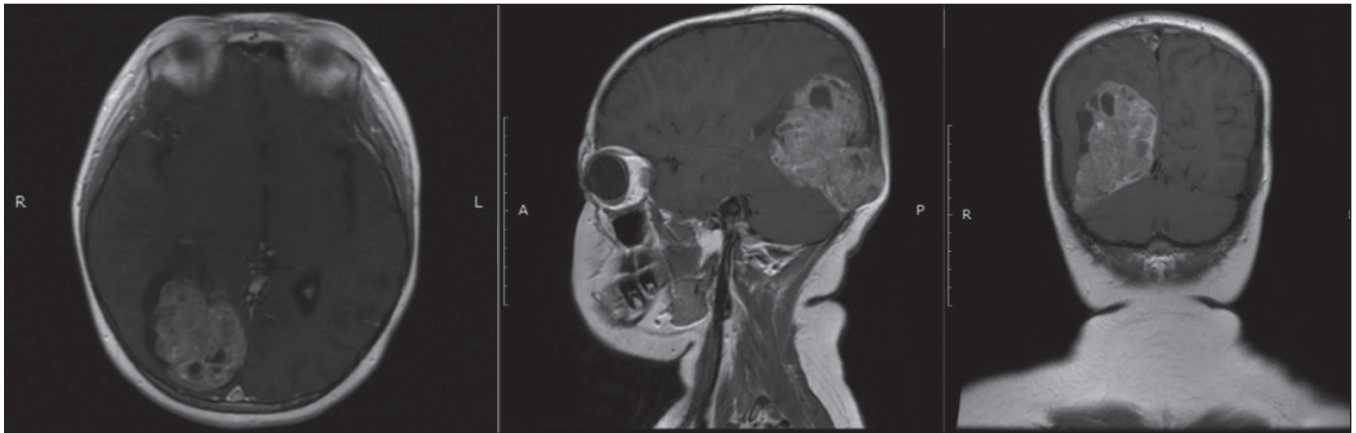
Contrasted brain MRI demonstrated solid mass with cystic component on the cortical and subcortical region of the occipital lobe with perilesional edema. After contrast administration, it showed rim contrast enhancement and bone destruction on the right occipital, suggesting a metastatic process
